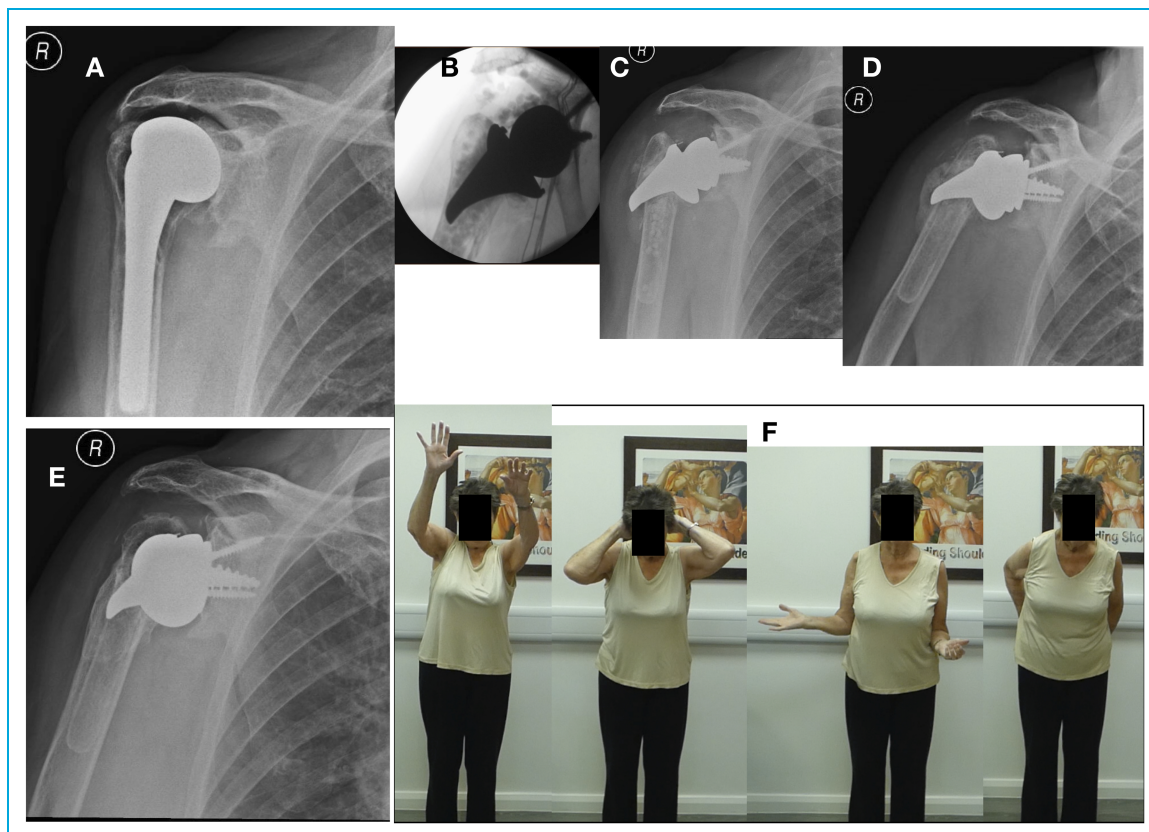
(Patient 9). (A) The stemmed Exactech Equinox Hemiarthroplasty with loosening. (B) Intra-operative X-rays of the revision with the stemless metaphyseal rTSA with stimulan beads. (C) Three weeks post-operative – tilting and perforation of the lateral cortex noted due to weak soft cortical bone. (D) The implant settled and remained stable in its new tilted position with conservative treatment, with new bone formation around the implants and solid fixation. (E) X-rays at 2 years follow-up post revision. Further new bone was formed with remodelling around the implant with solid long-term fixation. (F) Good clinical outcome – range of motion at the latest follow-up.
